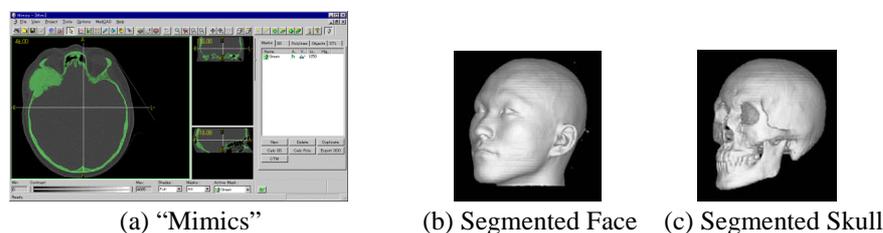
Data extraction from 3D-CT
